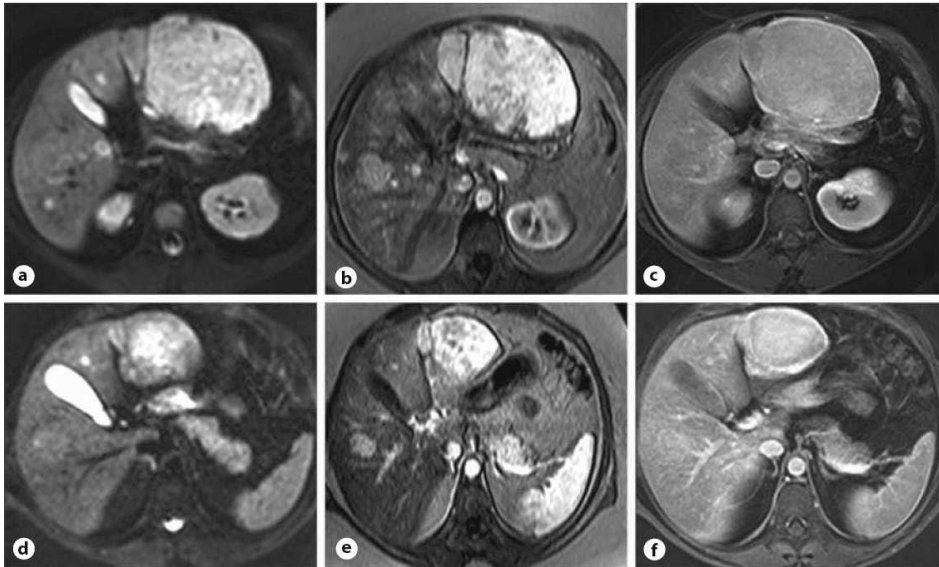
Contrast-enhanced multiphase MRI series of patient with HCA: (a) T2-weighted, (b) arterial phase, (c) delayed phase during use of OC, (d) T2-weighted, (e) arterial phase, and (f) delayed phase after stopping use of OC.
